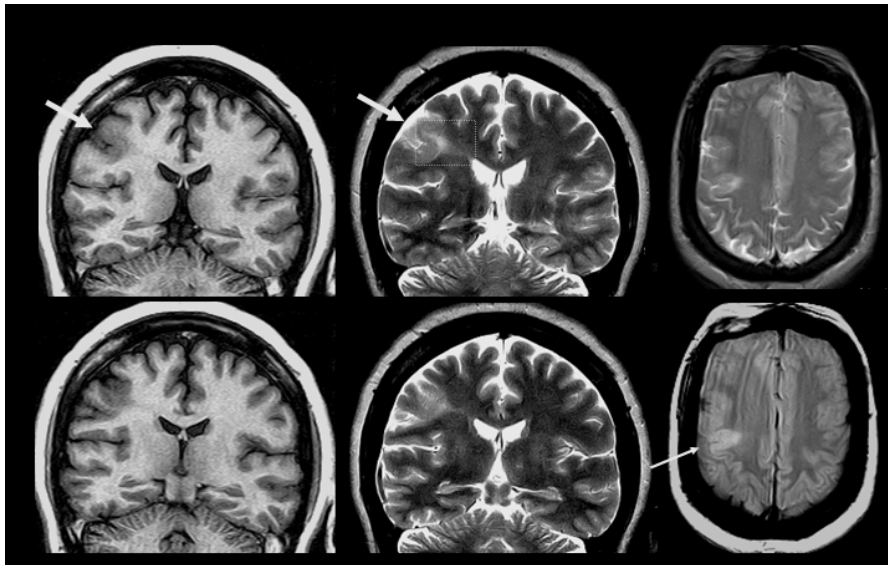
Coronal inversion recovery an T2 weighted, and axial T2 weighted and proton density MRI showing typical findings in focal cortical dysplasia (arrows): Cortical thickening and blurring of the gray-white matter junction, accompanied by focal gyral abnormality, alteration in the width and shape of a gyrus (arrow); prolongation of T2 relaxation time in the underlying white matter and radial signal abnormalities extending from the affected cortical surface towards the ipsilateral ventricle or *transmantle sign* (box).
